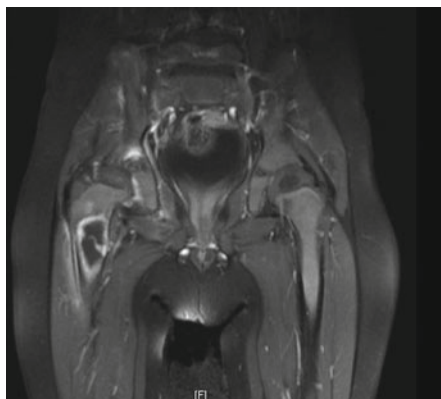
MRI pelvis: Enhancing mass lesion in the proximal diaphysis of the right femur, associated with periostitis surrounding soft tissue edema and enhancement of the adjacent femoral muscles
